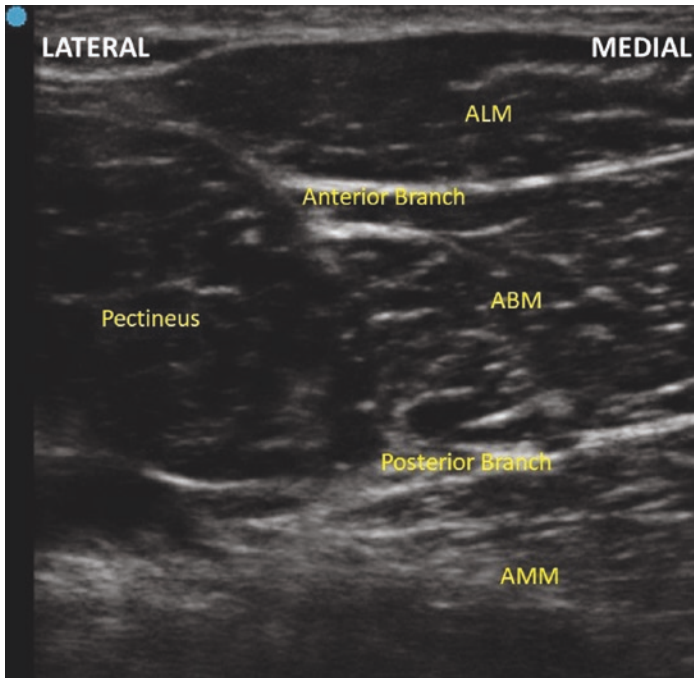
Obturator nerve ultrasound. The anterior branch of the Obturator Nerve is between the adductor longus muscle (ALM) and the adductor brevis muscle (ABM). The posterior branch of the Obturator Nerve is between the adductor brevis muscle (ABM) and the adductor magnus muscle (AMM)
